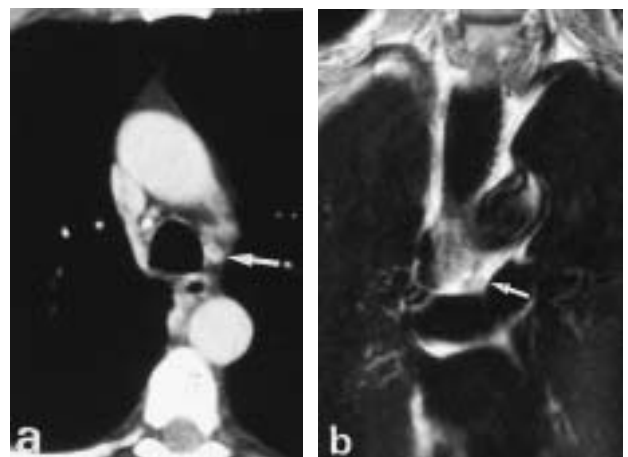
Aorto-pulmonary lymph nodes. a) Thin-section computed tomography with good contrast bolus, suspicion of small mediastinal lymph nodes, partially calcified, in the level of the aorto-pulmonary window (arrow). b) Coronal T1-weighted magnetic resonance image clearly demonstrates three small lymph nodes without partial volume effects (arrowhead).
